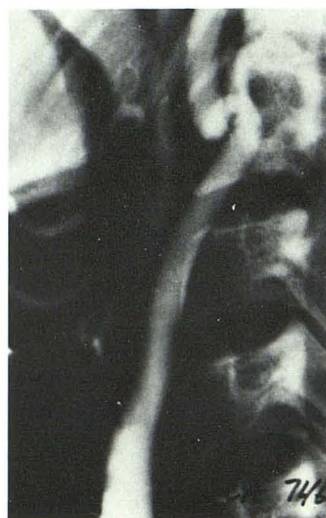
Anteroposterior arteriogram. Normal medial curvature of internal carotid near mandible (arrows). Vessel position alters angle of incidence of sound beam and results in increased pitch of Doppler signals. Change in pitch should not be mistaken for internal carotid stenosis.
